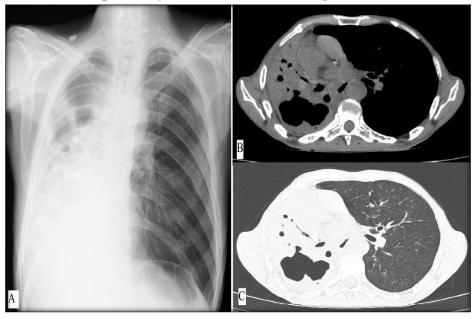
Chest radiograph (A) and CT (B&C) showing right lung destruction with residual bronchiectasis.
